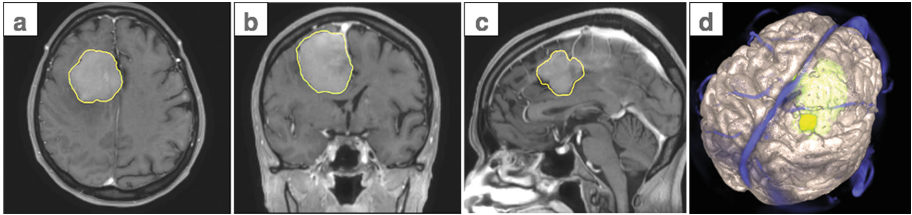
Processed gadolinium T1 MRI from left to right: axial (a), coronal (b) and sagittal (c) slices showing the manually segmented tumour outline. (d) The 3D view shows the extracted cortical surface, vessels (purple) and segmented tumour (green). (Color figure online)
